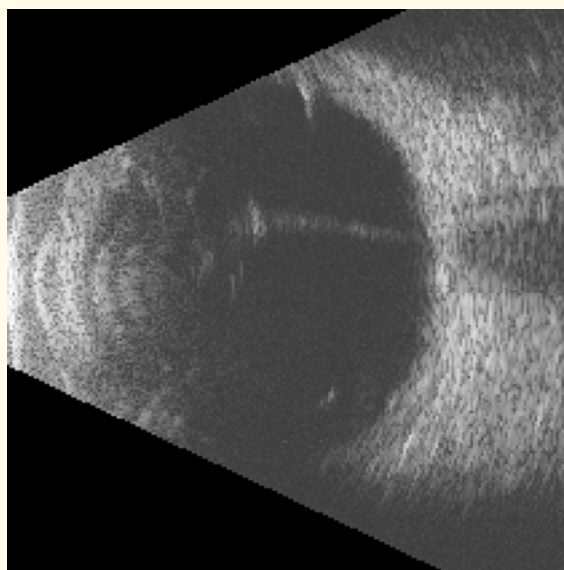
B scan ultrasound of the left eye demonstrating persistent hyaloid vasculature extending to anterior, retrolental fibrotic tissue.
